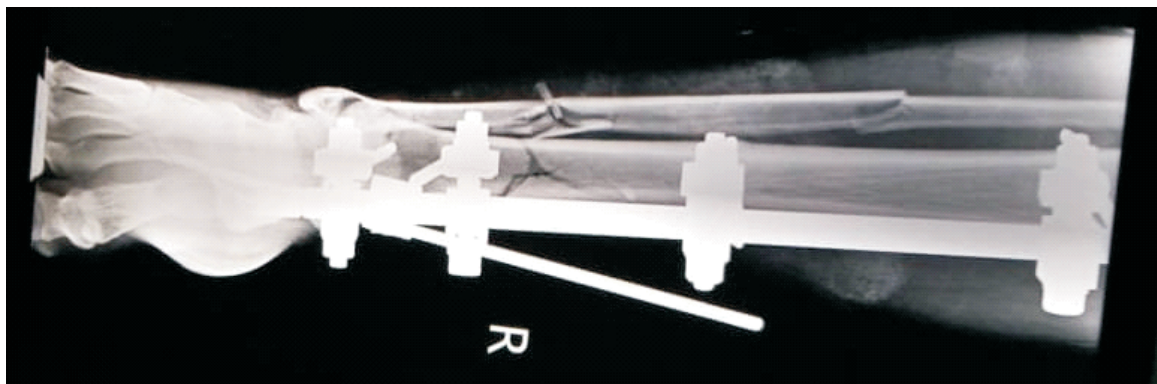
Post-operation Xray (A/P view) of the limb of the Patient in 2A & B.
